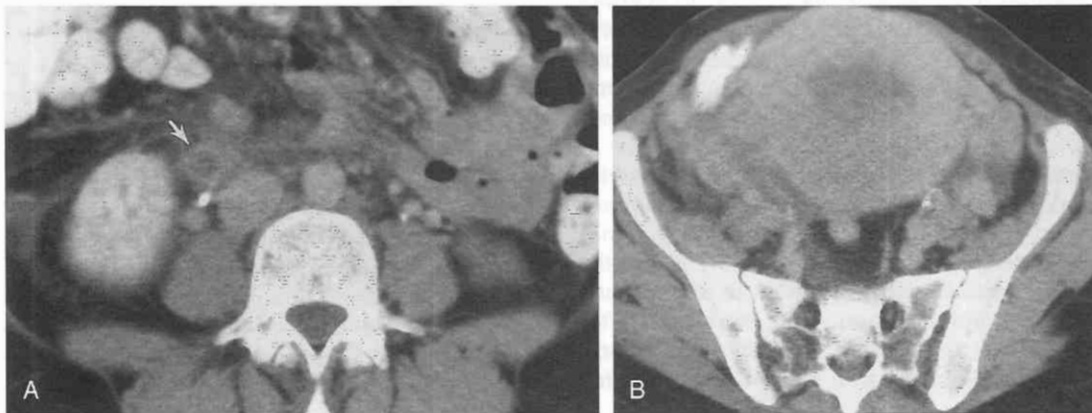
Gonadal vein thrombosis. *A*, Contrast-enhanced CT scan shows low-attenuation material within the lumen (arrow) of the right ovarian vein in a 22-year-old woman in whom a fever developed 24 hours after delivery. The wall of the vein is enhancing. The appearance is specific for venous thrombosis. *B*, A CT image through the pelvis reveals the enlarged uterus after delivery.
